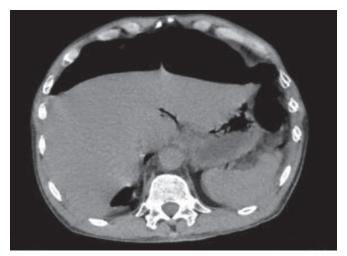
Pneumoperitoneum in simple abdominal computed tomography (CT)
